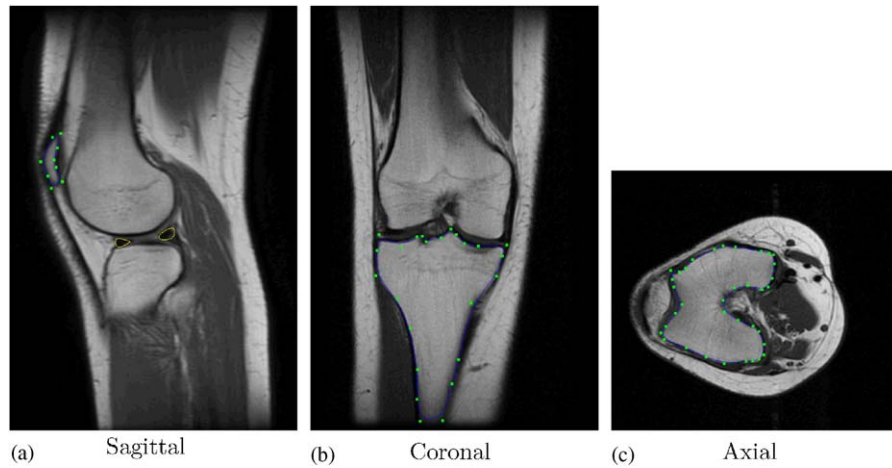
MR images. (a) Sagittal, (b) Coronal and (c) Axial.
